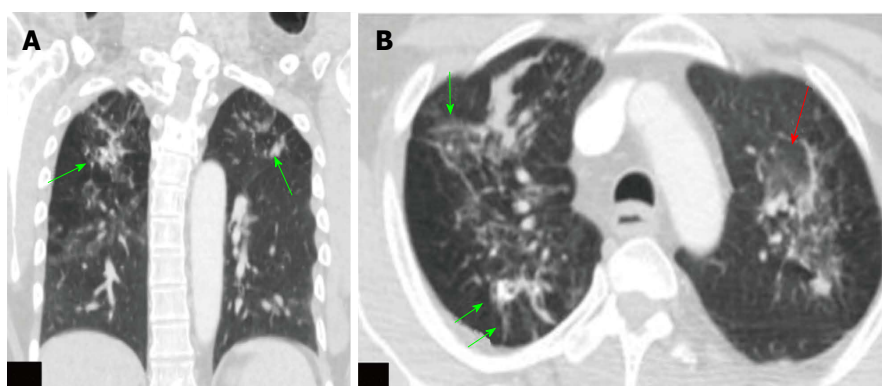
Computed tomography thorax images of the positron emission tomography-computed tomography scan. A: Coronal CT scan image of the thorax in lung window; B: Axial CT scan image of the thorax in lung window at upper thorax. These images show ground glass opacities (red arrow) with multiple soft tissue density nodules (green arrow), fibrotic changes and calcified granulomas in both the lungs. Features are suggestive of active tuberculosis. CT: Computed tomography.
